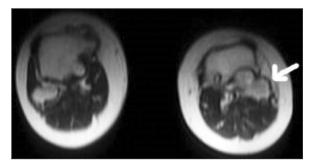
Magnetic resonance imaging of the exostoses in the head of the fibula is shown with white arrow.
